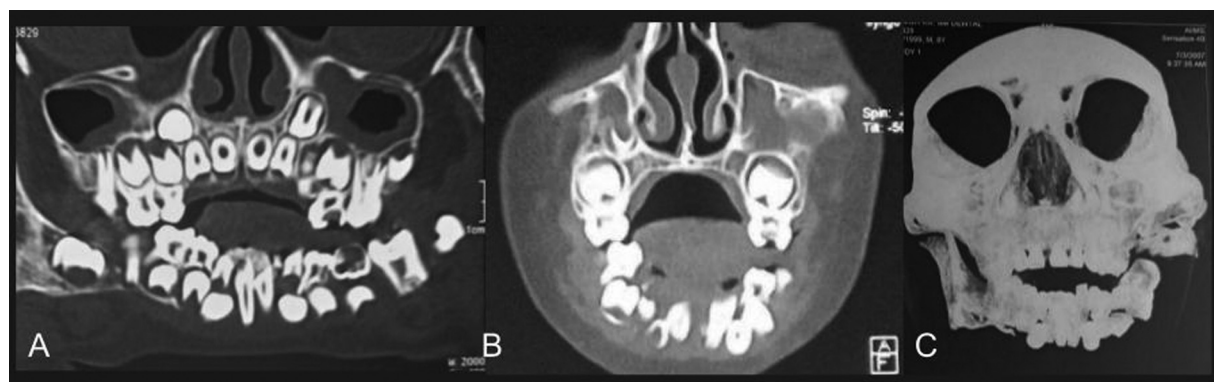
Langerhans cell histiocytosis (LCH). Panoramic (A), coronal (B), and volume-rendered reconstruction (C) computed tomography (CT) images shows near-complete osteolysis of the mandible with floating mandibular teeth characteristic of this pathology.
